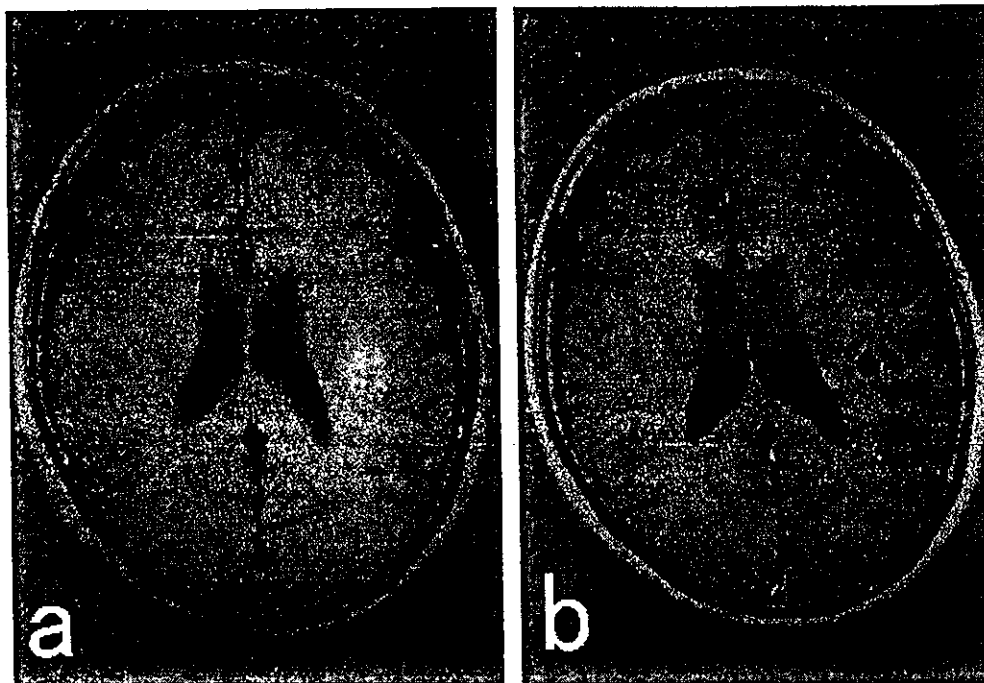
Findings of brain MRI. a. Brain metastasis after 13 cycles of Weekly T. b. The brain metastasis resulted in necrosis by gamma-knife and treatment with CAP.
